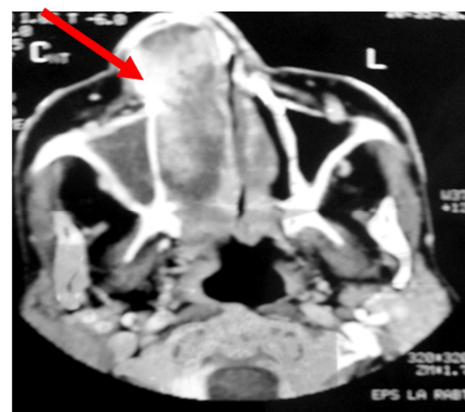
Computerized Tomography (CT) head and neck showing soft tissue mass (arrow) in naso maxillary sinus along with local bony destruction.
